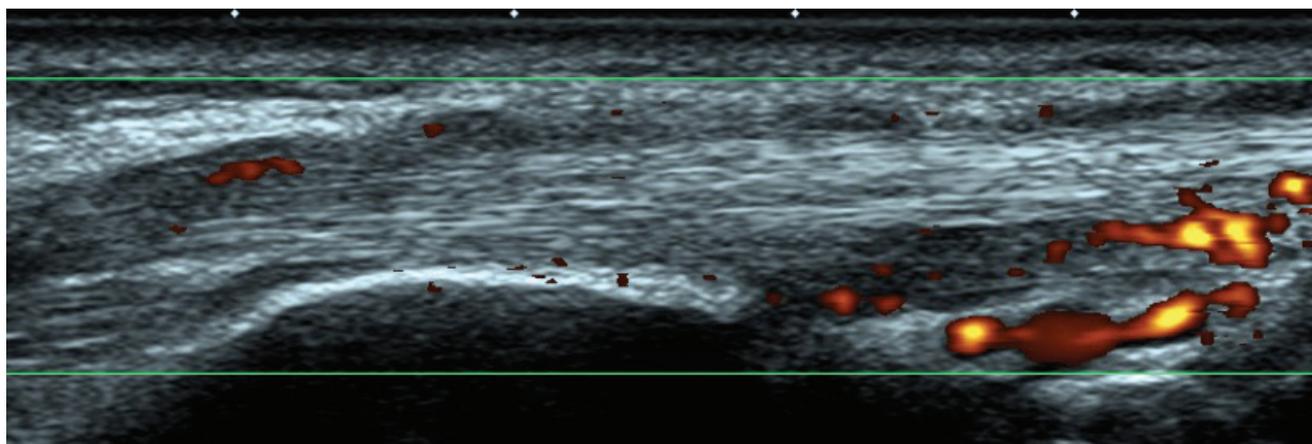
Ultrasound, longitudinal view of tenosynovitis of the extensor carpi ulnaris tendon
